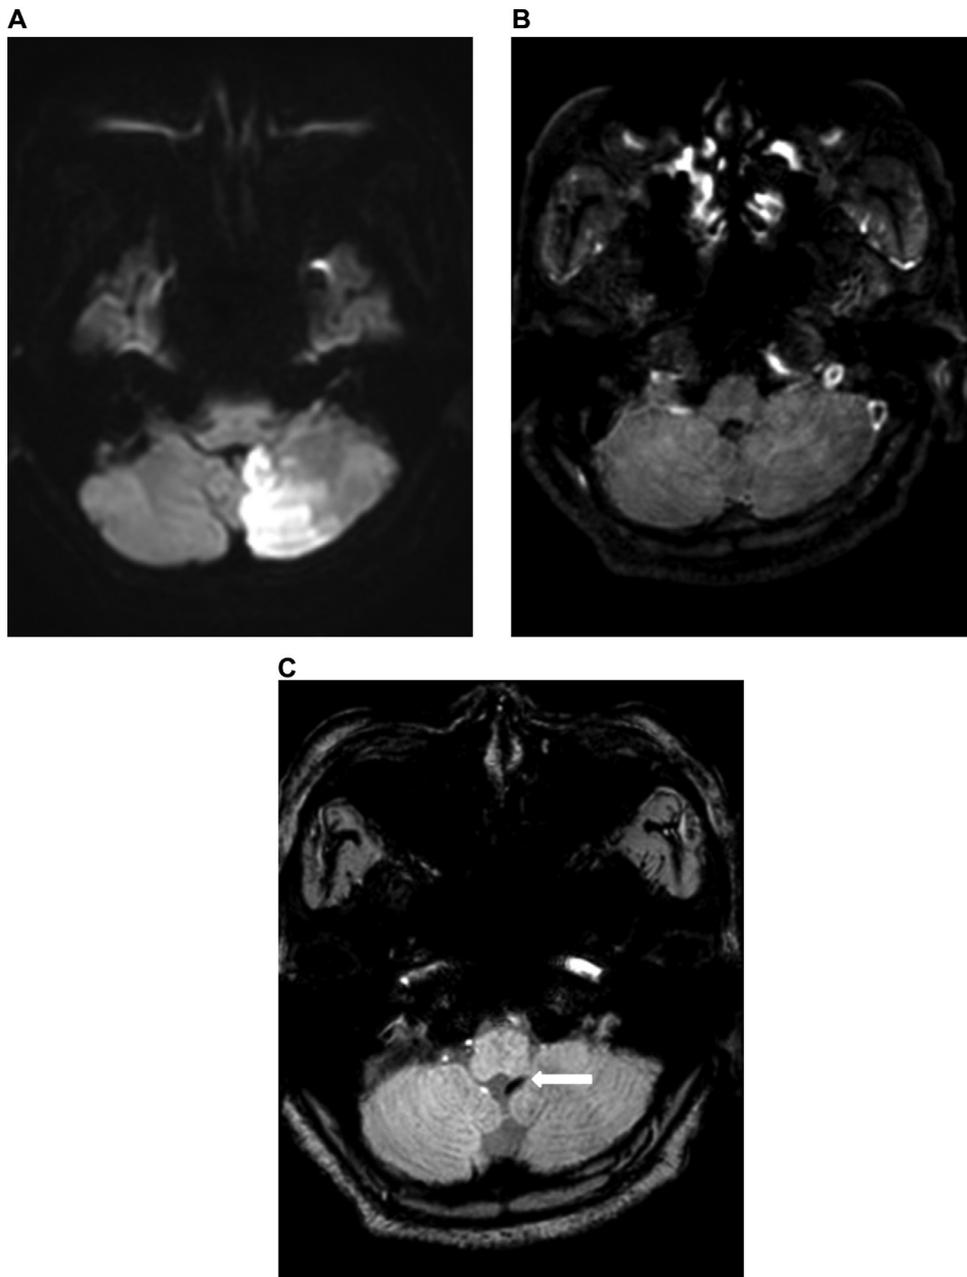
A 76-year-old woman with acute infarction of left posterior inferior cerebellar artery (PICA). A. Diffusion-weighted imaging shows acute infarction of the left PICA. B. 3D-BB-ceT1-MRI does not show contrast stagnation C. SWI shows a positive SVS in the left PICA (arrow).
